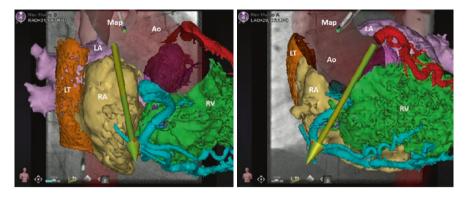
Ablation of an atrial tachycardia in a patient with functional univentricular heart who underwent lateral tunnel (*LT*) total cavo-pulmonary connection (TCPC) with surgical patch closure of the tricuspid valve. Access to the right atrium (*RA*, target chamber) is performed retrogradely via the aorta using remote magnetic navigation (Stereotaxis). The mapping catheter (*Map*) is guided remotely by directing the magnetic vector on the display (yellow/green arrow). The patient's unique anatomy is precisely depicted by 3D image reconstruction (in this particular case from contrast CT scan) and superimposed on the fluoroscopy images in right anterior oblique (RAO 30°, left panel) and LAO (30°, right panel). Simultaneous visualization of the coronary arteries (left coronary artery *in red* and right coronary artery *in blue*) permits a safer approach during radiofrequency ablation. *Ao* aorta, *LA* left atrium, *RV* right ventricle
